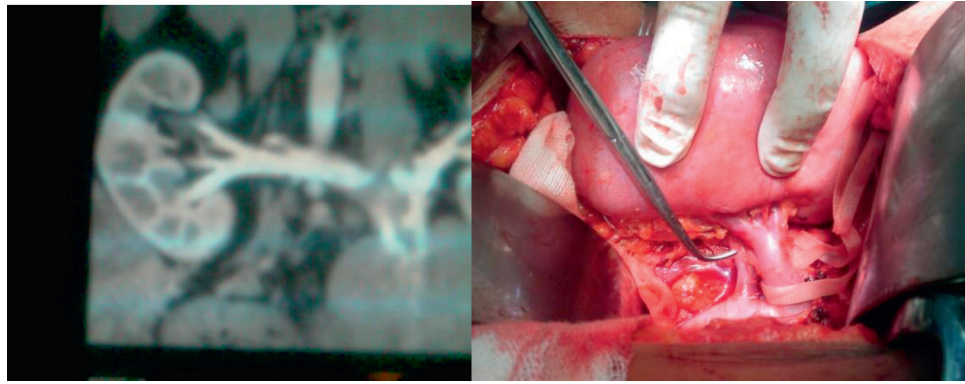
Multi-detector CT angiography in 26-year-old male renal donor showing single right renal vein with confluence near the renal hilum (A). During surgery a second large separate renal vein was detected (B).
